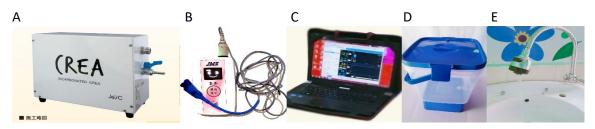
A. JesC CREA, BC2000, B. Laser Doppler Flowmetry, C. Computer (Toshiba) D. Plastic Container, E. Sink (Water Source)
